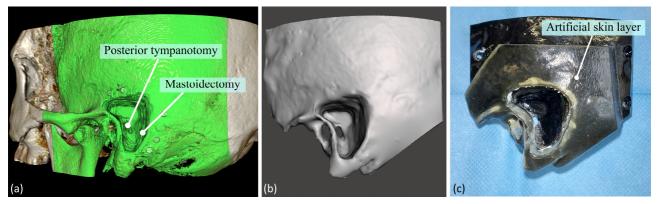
From CBCT temporal bone data to 3D printed model: (a) Segmentation in InVesalius; (b) Post-processing in Meshmixer; (c) 3D printed temporal bone including artificial skin layer.
